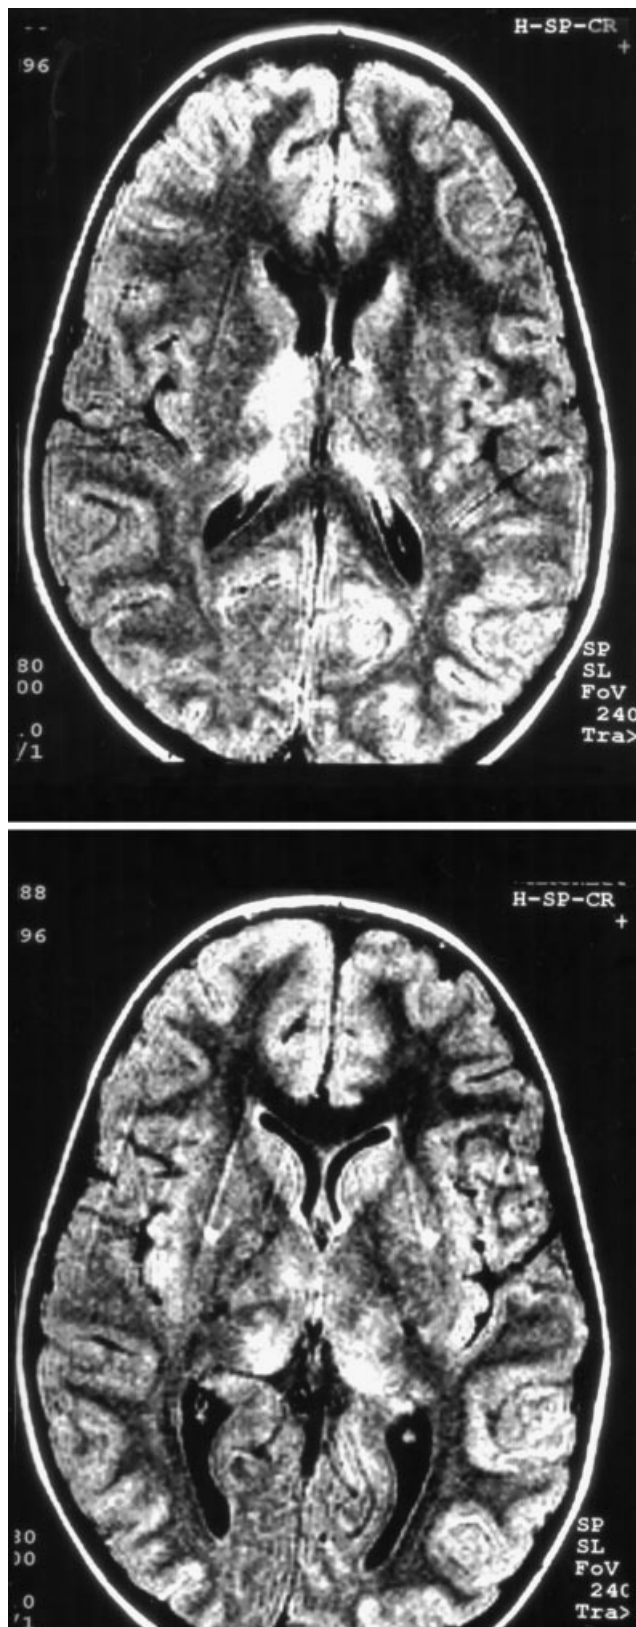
MRI of a patient with TBE: lesions predominantly in the thalamus.
